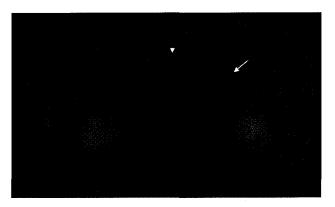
Transaxial F-18 FDG PET/CT images of the abdomen showed mild F-18 FDG uptake in left paraaortic (maxSUV 1.67) (arrow) and aortocaval (maxSUV 1.6) (arrowhead) lymph nodes.
